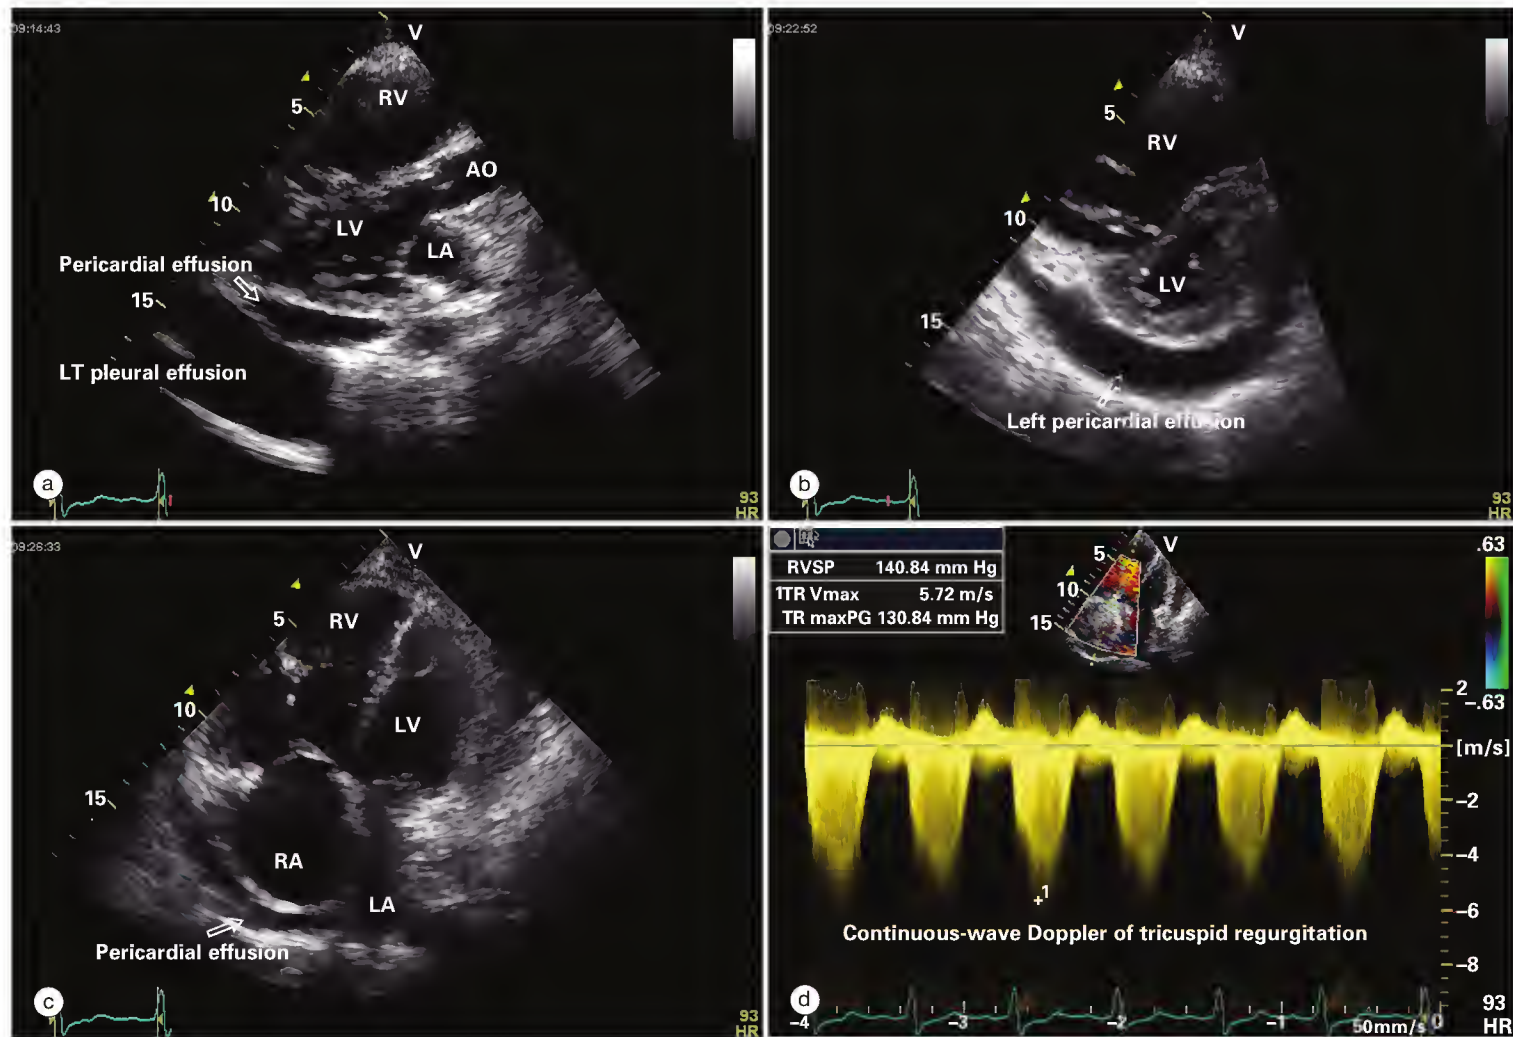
Echocardiographic images for a woman with limited cutaneous systemic sclerosis and pulmonary arterial hypertension. (a) Parasternal long-axis view shows left ventricle, dilated right ventricle, and presence of both a left pleural and pericardial effusion. (b) Parasternal short-axis view demonstrating the D-shaped septum seen with pressure overload of the right ventricle. The right ventricle is dilated and again visible is a moderate-sized pericardial effusion. (c) Apical three-chamber view showing dilated right-sided chambers and a pericardial effusion. (d) Continuous-wave Doppler image of tricuspid valve regurgitation with an estimated peak right ventricular systolic pressure of 141 mm Hg plus right atrial pressure.
